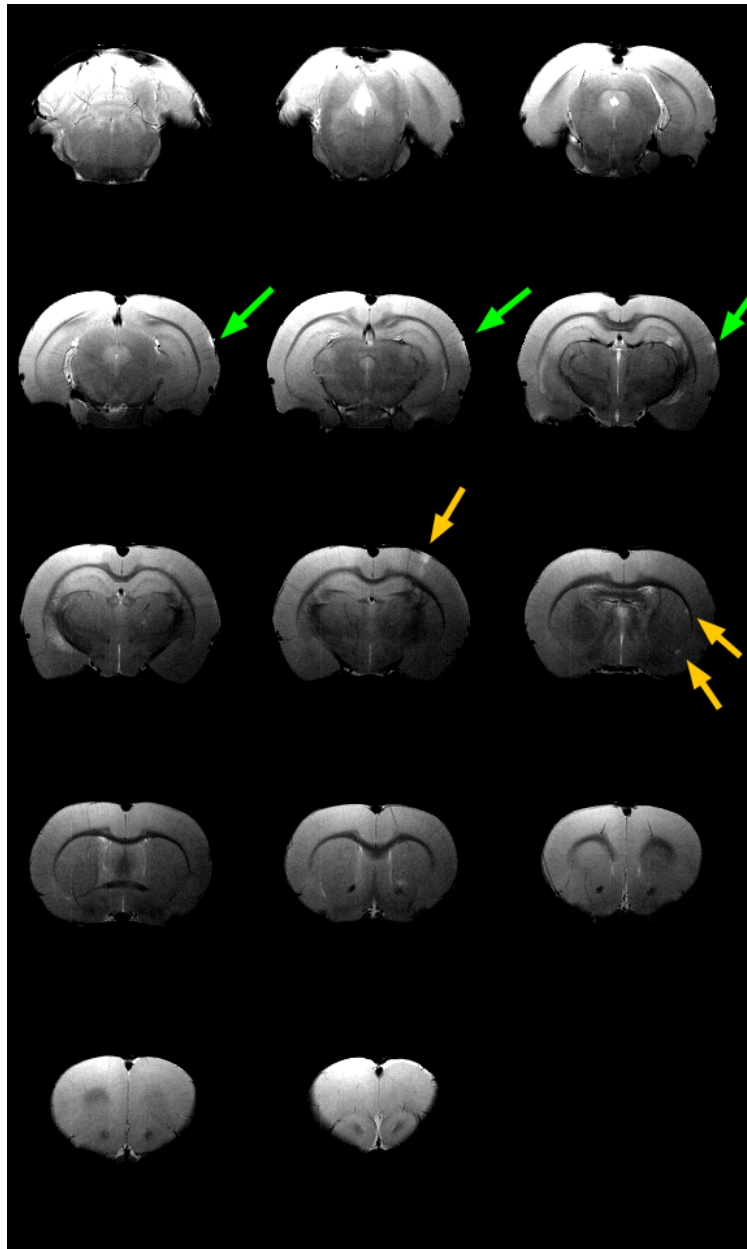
MR T₂ weighted images 24h after 0.25×10^6 MSCs intra-arterial delivery. Green arrows point lesion induced by positioning the Doppler probes and orange arrows point ischemic lesions produced by 0.25×10^6 cells intra-arterially administrated.
